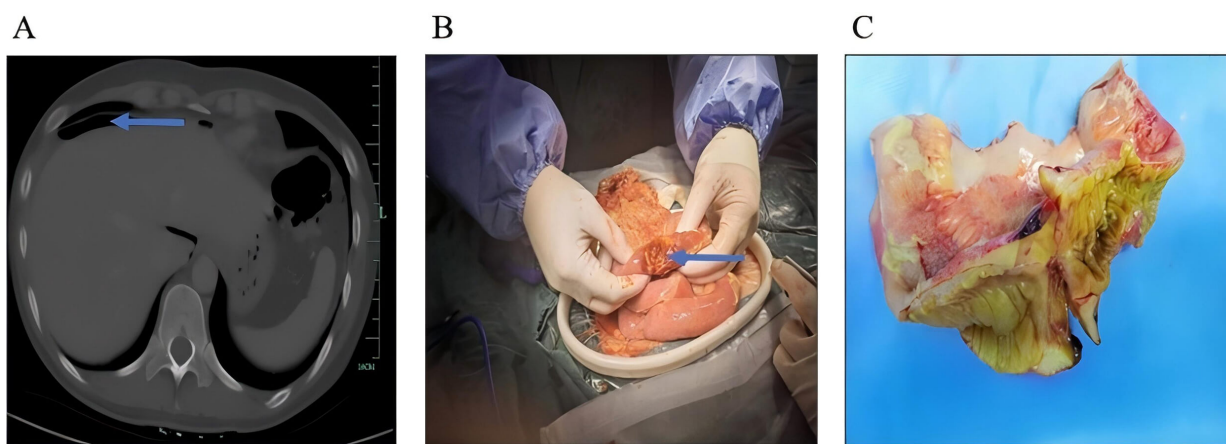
Computed tomography (CT) scan and the intraoperative perforation. (A) CT scan showing free gas in the abdominal cavity, indicated by the arrow; (B) Perforation in the ileum found during surgery, indicated by the arrow; (C) Markedly thickened intestinal wall and mesentery in the vicinity of the perforation.
